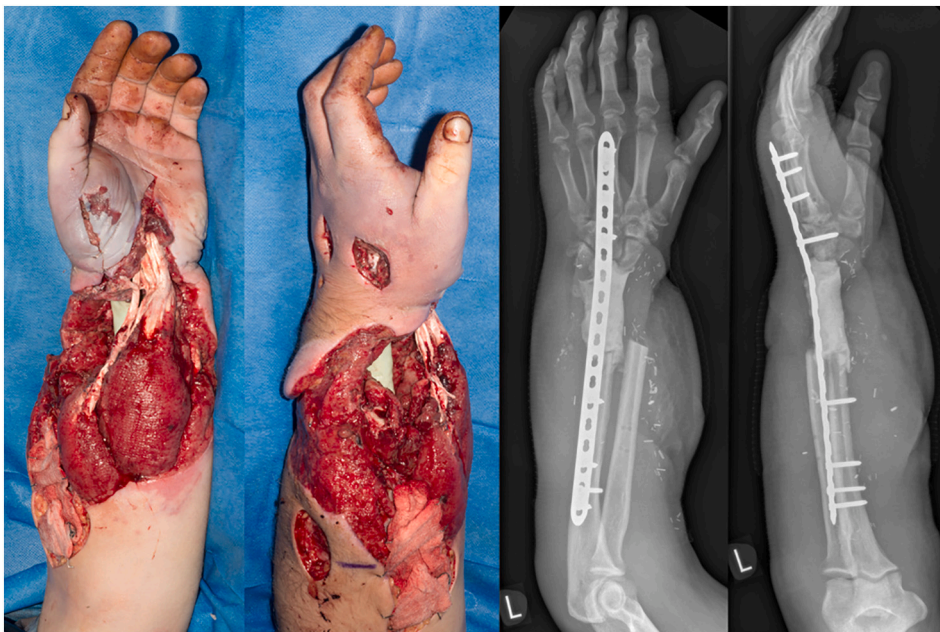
Clinical photographs and x-rays after cement spacer insertion.
